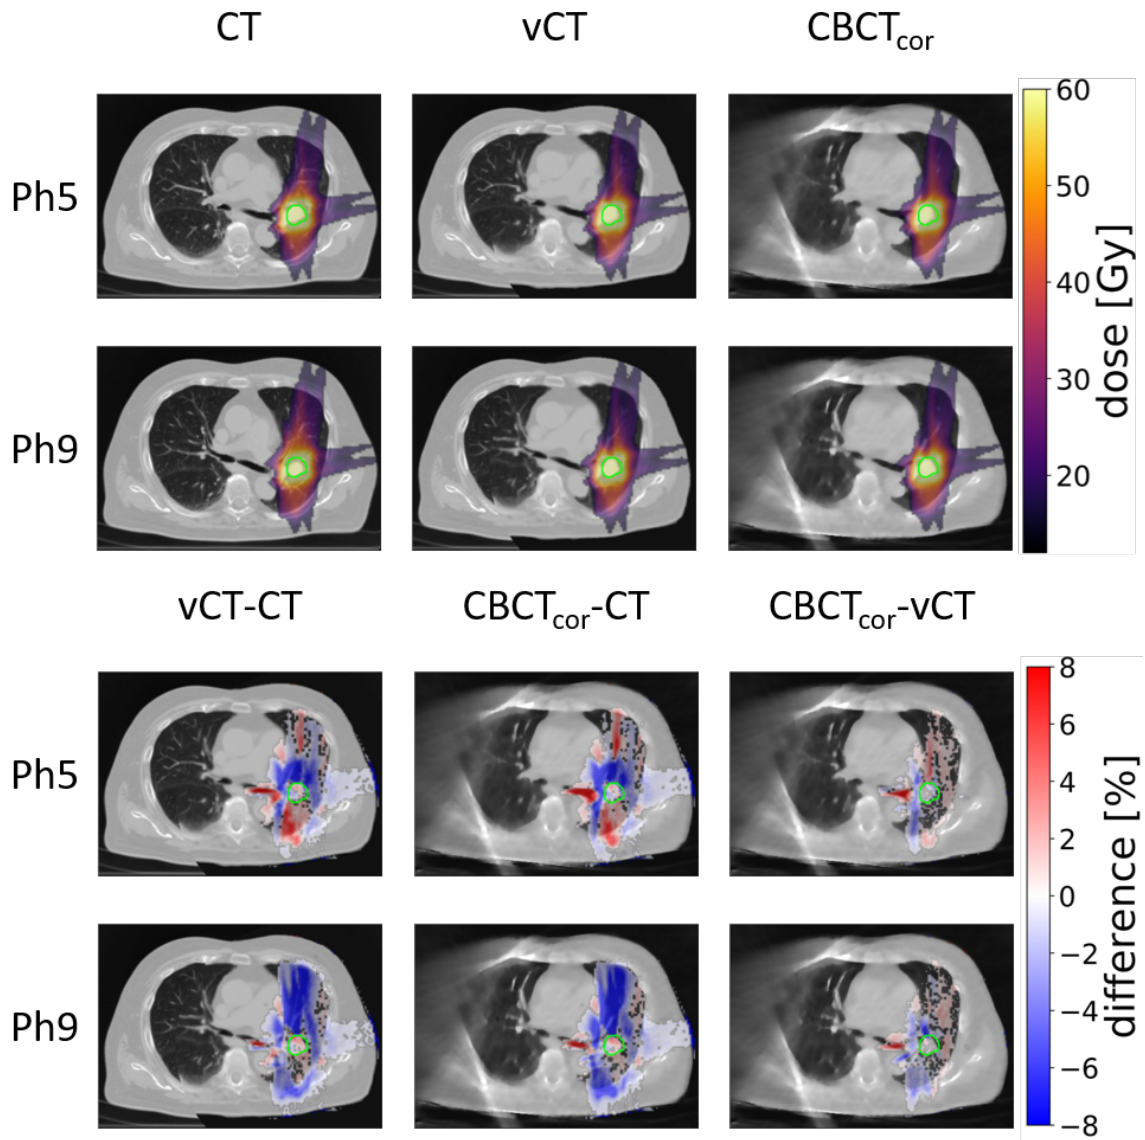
Recalculated proton dose distribution on extremal phases of 4DCT, 4DvCT, and 4DCBCT_{cor} of patient 14 are shown in the top two rows. The bottom two rows display dose difference plots, which are expressed as a percentage of the prescribed dose. To improve the clarity of the plot dose difference values smaller than 0.4% are masked. The vCT is stitched with the CT in areas outside of the CBCT FOV.
